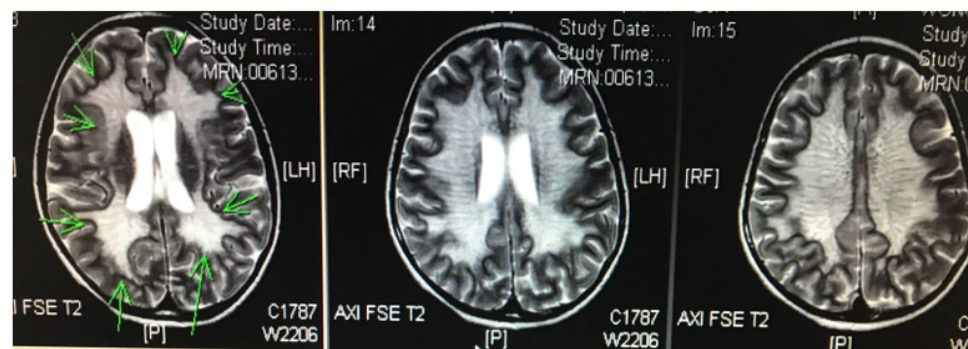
Brain MRI revealed diffusely abnormal signal of white matter of the brain bilaterally, that may count into demyelinating disease.
